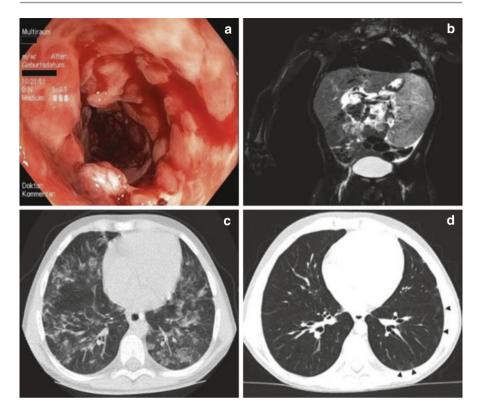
Intestinal, pulmonary, and splenic alterations in LRBA-deficient patients. (a) Colonoscopy revealing severe circular inflammation in the rectum, numerous ulcerations, and mucosal edema and erythema. (b) Magnetic resonance image of marked splenomegaly. (c) High-resolution chest-computed tomographic scan showing atypical, partly conflating patchy alveolar consolidations in both lungs. (d) Marked regression of alveolar consolidation 2 years after therapy and slight bilateral ground-glass infiltrates (Obtained from *Gámez-Diaz et al. JACI, 2017*)
